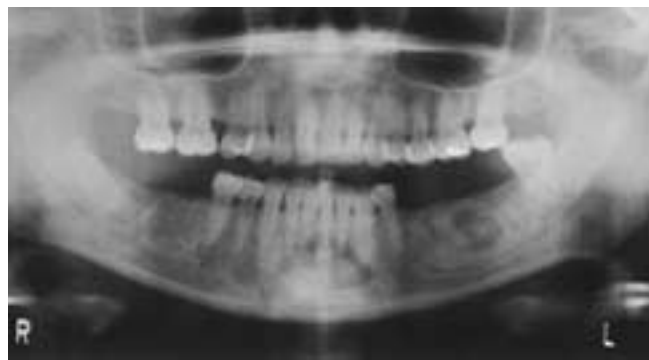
Periapical cemental dysplasia. Pantomogram of the mandible shows multiple sclerotic foci within the mandible, especially at the symphysis and body on the left. Some of these sclerotic areas merge imperceptibly with the mandible. Other densities are surrounded by a lucent ring. The radiographic appearance shows the evolution from lucent areas in the early stages, to mixed stages, and finally to the sclerotic stage.
